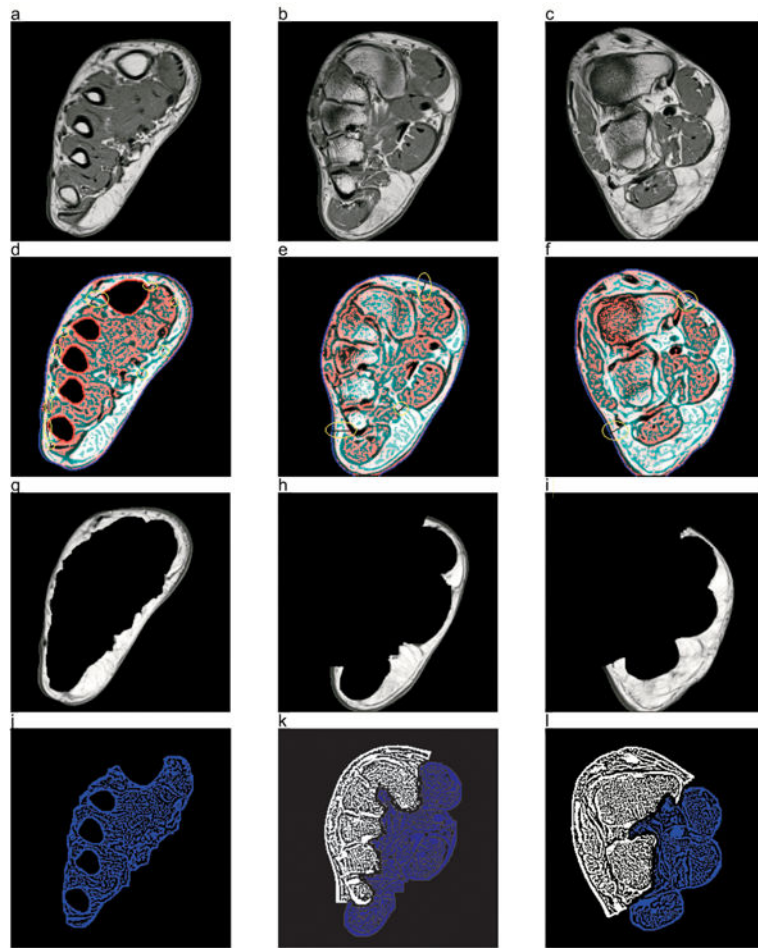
Segmentation methods of fore-(first column), mid- (second column), and hindfoot (third column). (a-c) MR image; (d-i) separation of subcutaneous fat; (j-l) remaining intrinsic foot muscle.
